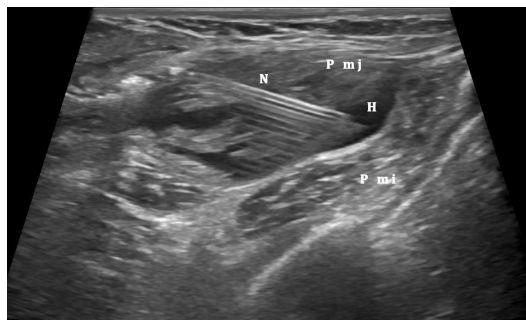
Ultrasound view of Intervention. N = needle; H = Hydrodissection; P mj = Pectoralis Major; P mi = Pectoralis Minor.
